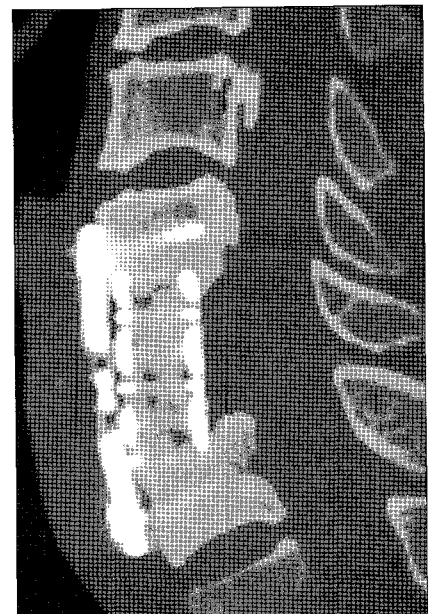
Postoperative sagittal reconstruction of axial computed tomography scans confirmed adequate graft/fusion cephalad and caudad within titanium mesh cage (TMC) 6 months after corpectomy and TMC augmented stabilization.
